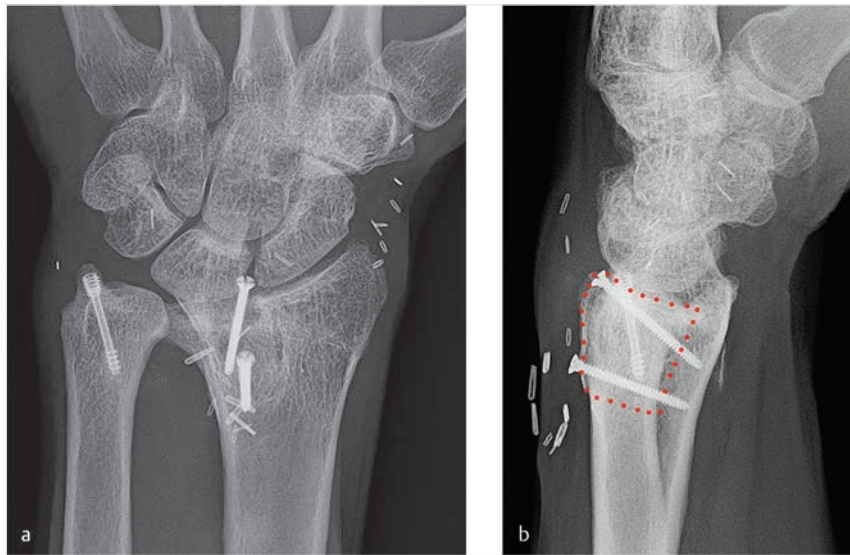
(a, b) Radiographs 2 years postoperative. The graft is shown (dots).
